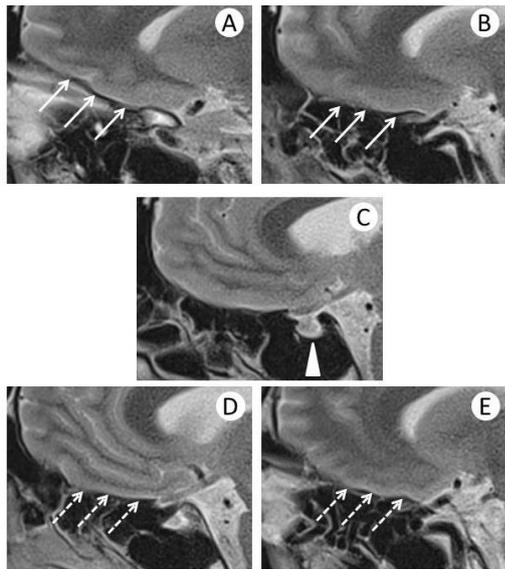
Sagittal T2-weighted MRI shows absence of the olfactory bulbs, tract, and groove (A, B, D and E). An apparently normal pituitary gland was detected (C).
